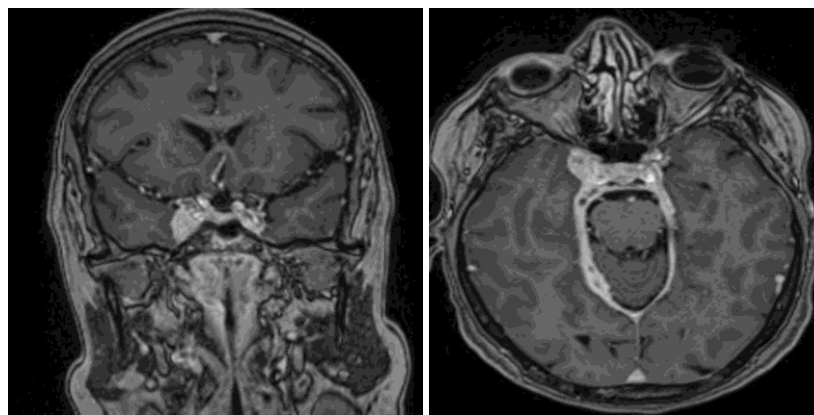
Follow-up coronal axial post-contrast T1-weighted MRI after four months of corticosteroid therapy, demonstrating regression of the lesion
